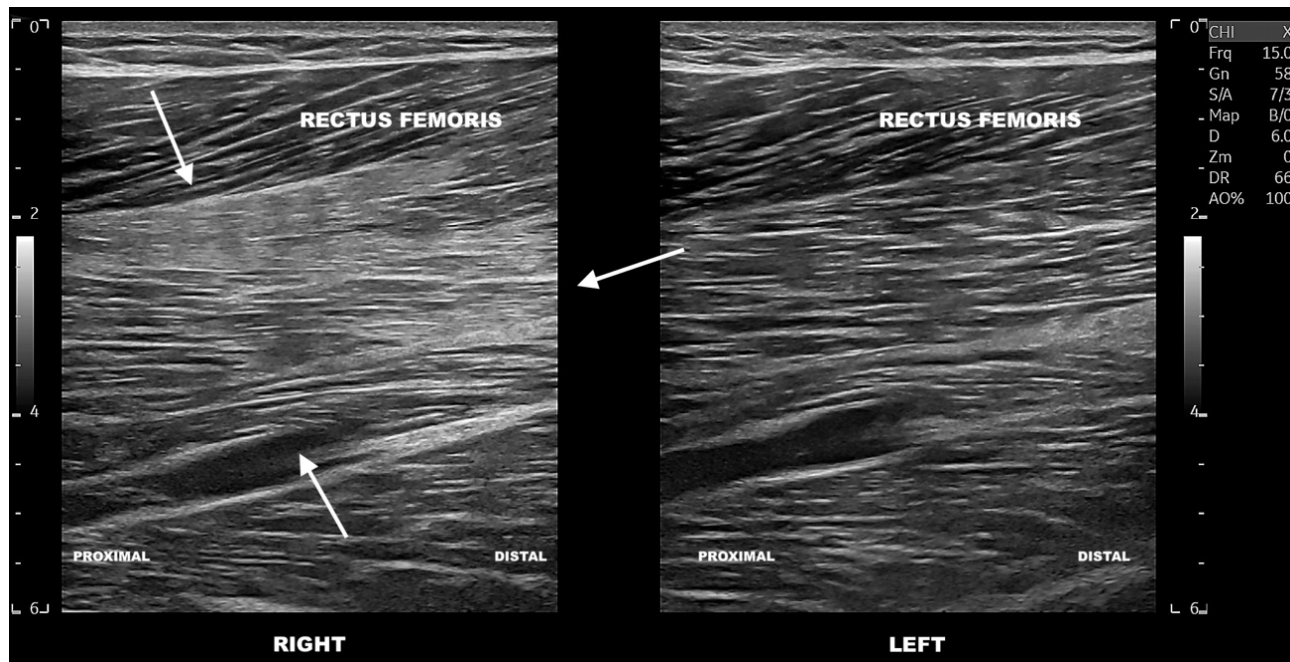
A 17-year-old male with sudden pain in the right thigh while playing a match. Comparative ultrasound images of the anterior region of the rectus femoris in the sagittal plane. The right side shows increased echogenicity and a lack of definition of the normal fibroadipose septa and fascicle pattern due to edema (arrows). SOMICS category 1 (score of 4).
